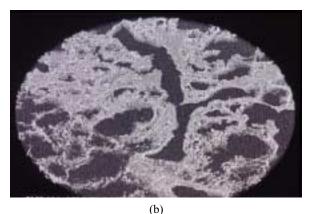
3-D display of the stacked Micro CT images of the abnormal lung tissue (pulmonary adenocarcinoma in emphysematous lung) Resolution : $24 \, \mu m$. (b) Resolution : $6 \, \mu m$.
